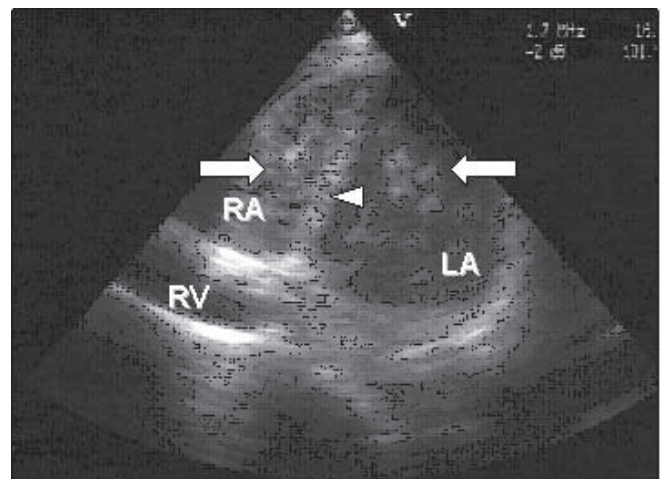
Echocardiography showing agitated saline contrast (arrows) on both sides of the atrial septum (arrowhead) consistent with a Right to Left shunt. RA=Right Atrium. RV=Right Ventricle. LA= Left Atrium.
